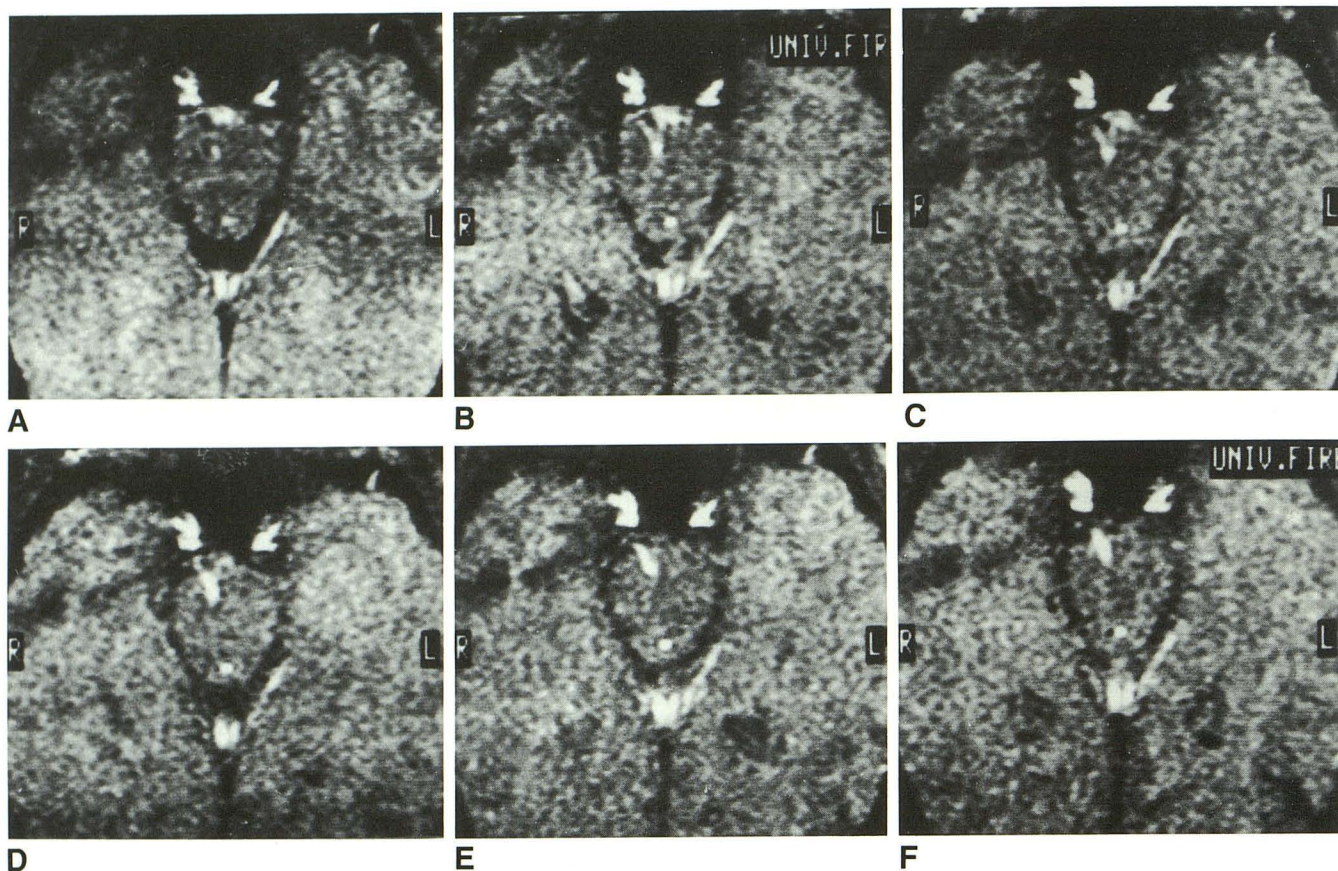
A–F, Fifteen serial (every 50 msec) fast multiphase gated MR images in a healthy volunteer. The first frame (A) corresponds to a delay time of 280 (trigger delay time + echo time + 250 msec) from the R wave, the last one (F) to a delay time of 980 msec.
